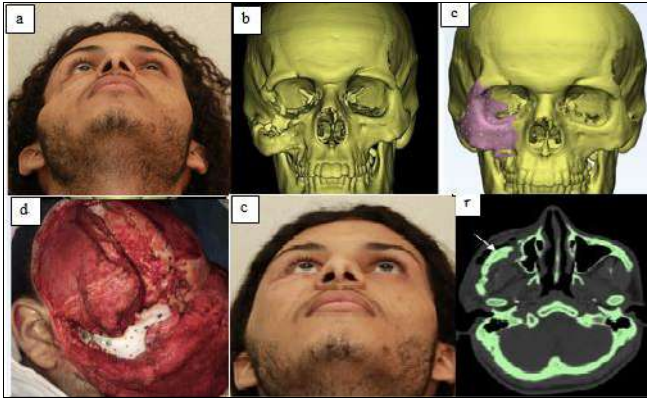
(a) Basal view of the patient showing the severe asymmetry in right side. (b) 3D radiological model showing deficient zygomatic bone. (c) 3D reformatted image showing the planned implant which will cover the defect totally. (d) Intraoperative photo showing extended bicoronal incision showing the PSI fixed to the zygoma arch remnant (e) Postoperative view showing restored facial asymmetry. (f) Axial CT cut showing in-place PSI “white arrow” with minimal difference from the other side.
